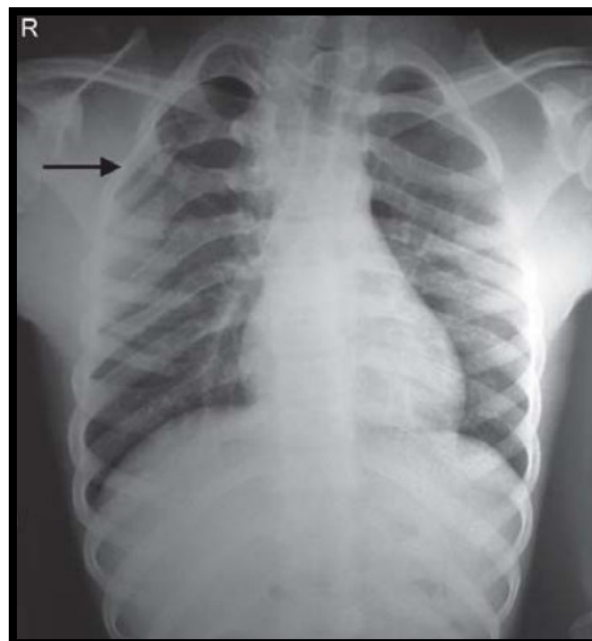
A posteroanterior (PA) view of a chest X-ray reveals a distortion in the vertebral rib in the cervicodorsal area. Adapted from (Singh Dhull et al., 2013).
